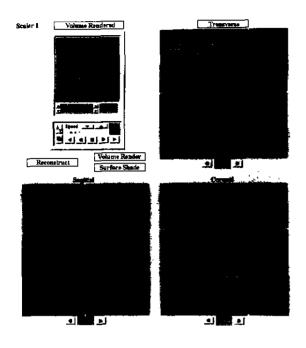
<sup>99m</sup>Tc SPECT early image of a patient. The left upper lobe mass can be seen in each slice and reconstruction image, preoperative diagnosis: lung cancer (false positivity case). Pathological diagnosis: pneumonia.
